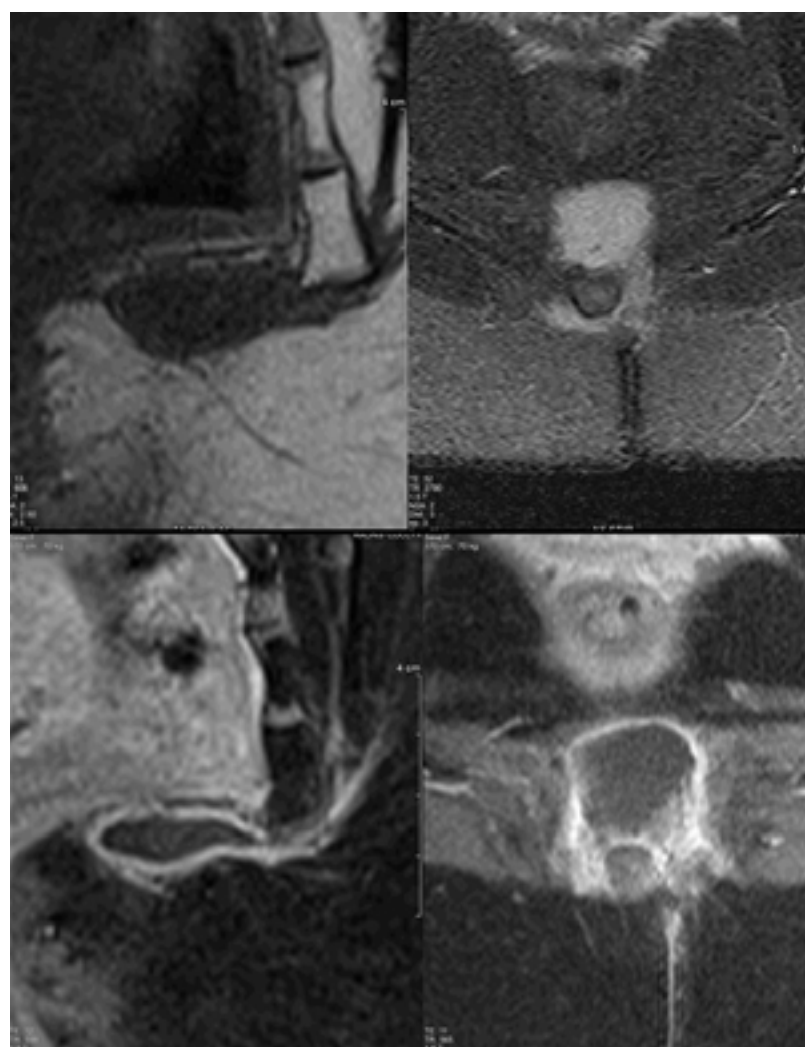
Sagittal T1 MRI section, axial STIR, sagittal and axial T1 with fat saturation. Hypointense postoperative collection in T1, hyperintense in T2 and peripheral enhancement after injection of liquid.
